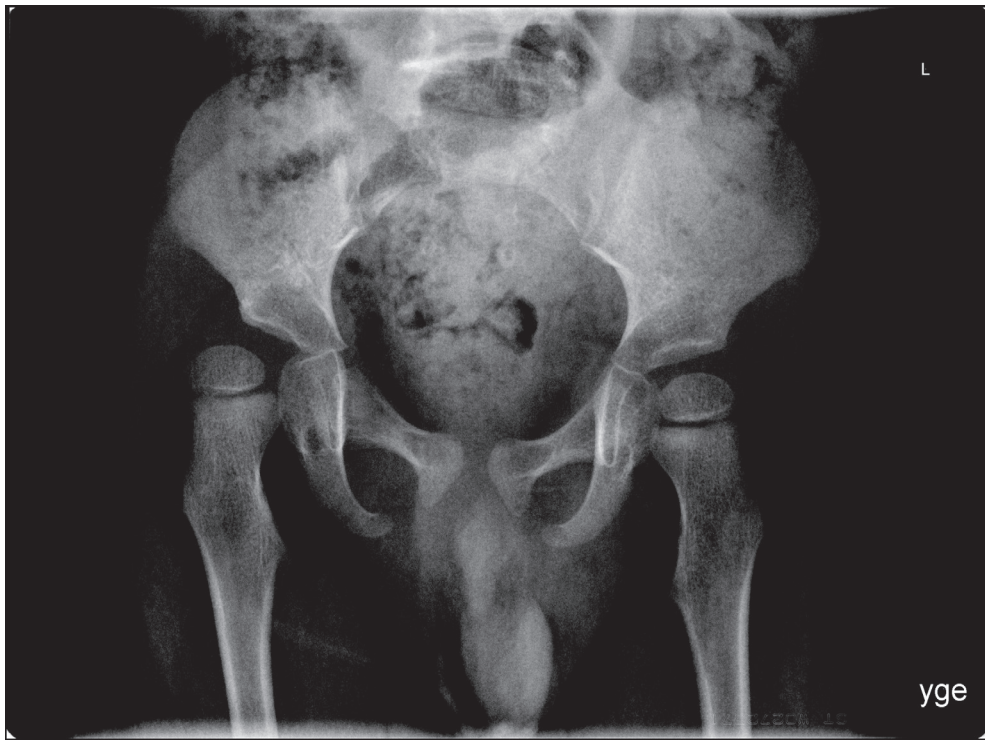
X-ray of the pelvis in May 2012, age 2 years 11 months.
